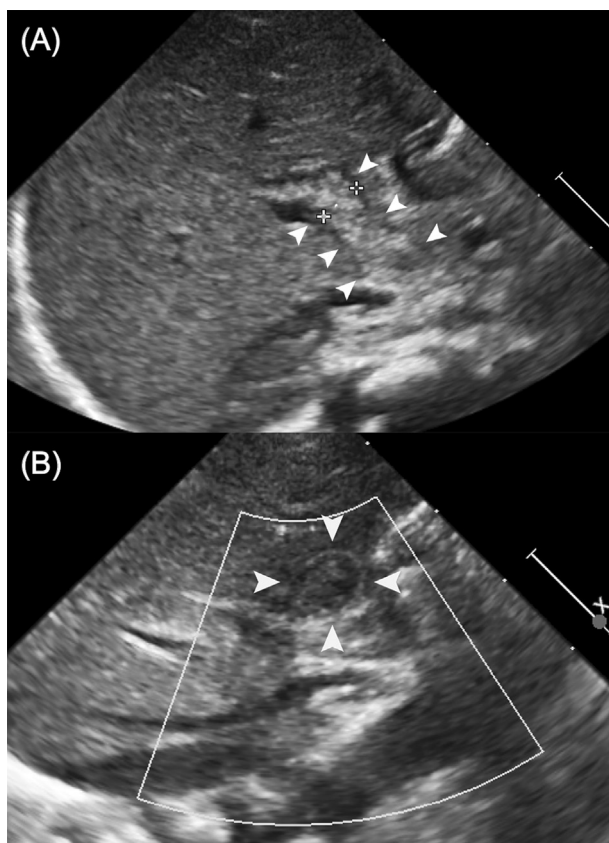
Abdominal ultrasonography showed mild intrahepatic biliary dilatation and a dilated common bile duct (CBD) (6 mm) filled with a slurry-like substance (A; indicated by arrow). A transverse ultrasound scan of the CBD showed that it was dilated and filled with slurry (B).
